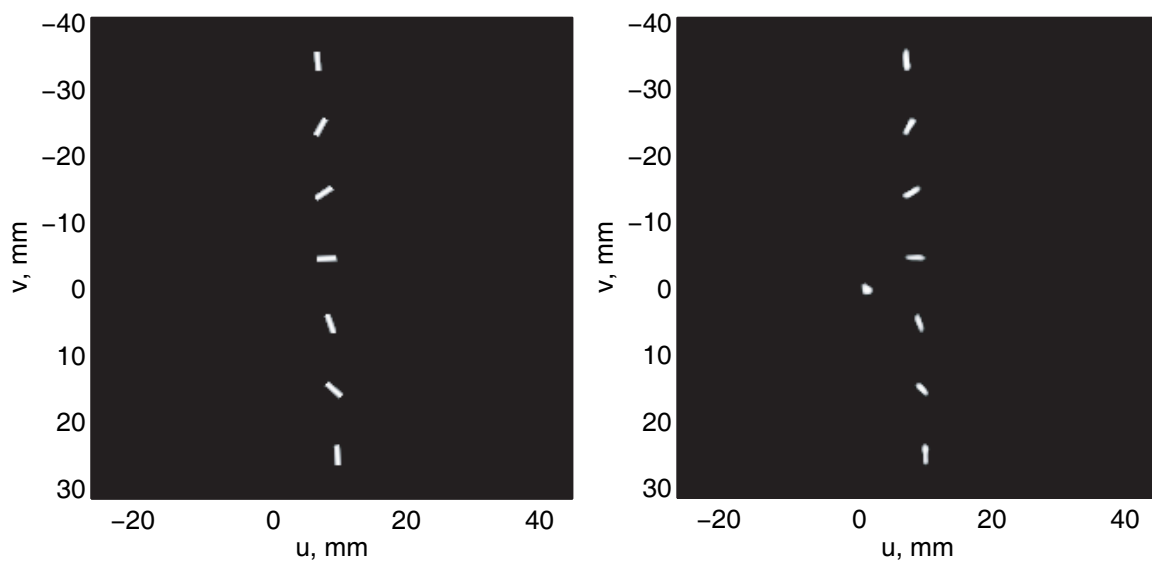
Marker model DRR for of a CBCT image of the RSVP (*left*) and the corresponding MEF-image (*right*).
